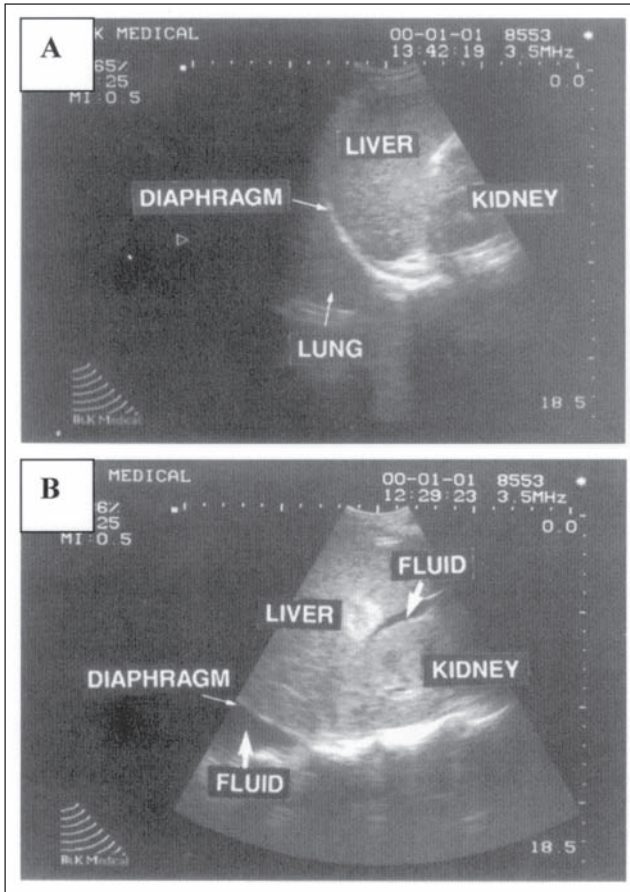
A) Normal right thoracic view. B) Positive right thoracic view, with traumatic hemothorax and hemoperitoneum. (From Sisley AC, Rozycki GS et al. Rapid detection of traumatic effusion using surgeon-performed ultrasonography. *J Trauma* 1998; 44:291, with permission.)
